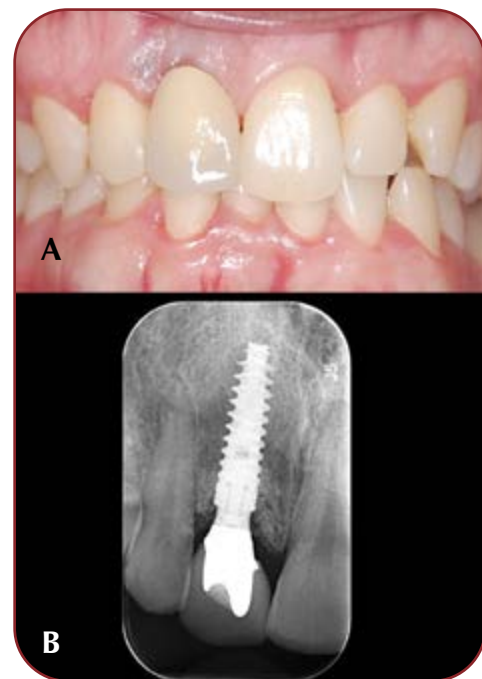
Final result: A. Retroalveolar x-ray; B. Intraoral view of the restoration
